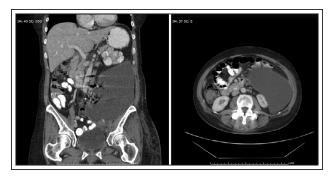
Coronal and axial CT images taken on POD #27 revealing large left-sided retroperitoneal fluid collection.
